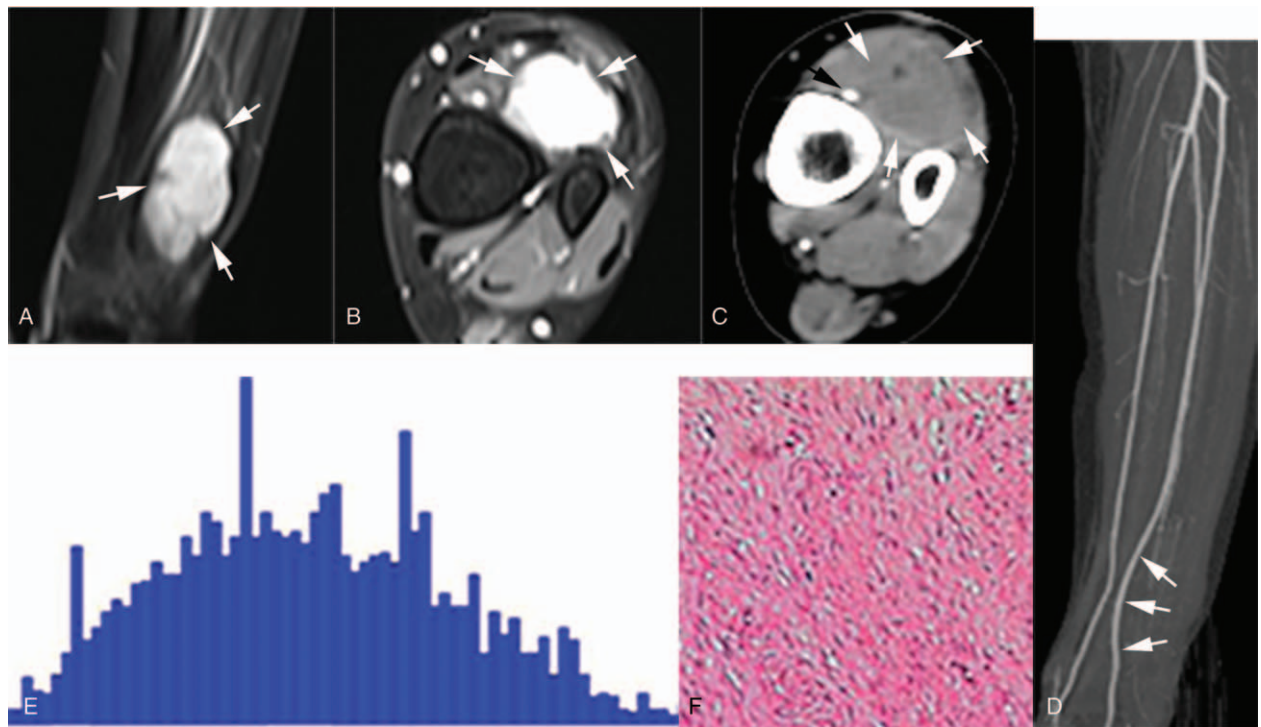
A 26-year-old woman with a mass in the left calf. The tumor boundary could be easily identified on both coronal (A, arrows) and axial (B, arrows) contrast-enhanced T1-weighted MR images, but was unclear on the CTA image (C, arrows). The medial displacement of the anterior tibial artery was better depicted on the reconstructed CTA image (D, arrows) compared with the CTA source image (C, black arrow). Kurtosis, skewness, and inhomogeneity derived from the histogram (E) were 0.17, 0.29, and 0.21, respectively. The pathology showed a fibroma (F). CTA=computed tomography angiography.
